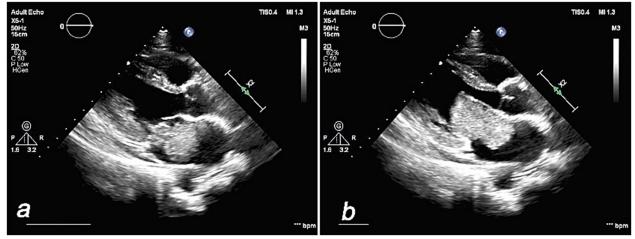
(a and b) Presurgical 2D transthoracic echocardiography showed a cardiac mass located in the left atrium, with imprecise margins, attached to the interatrial septum. 2D: Two-dimensional.
